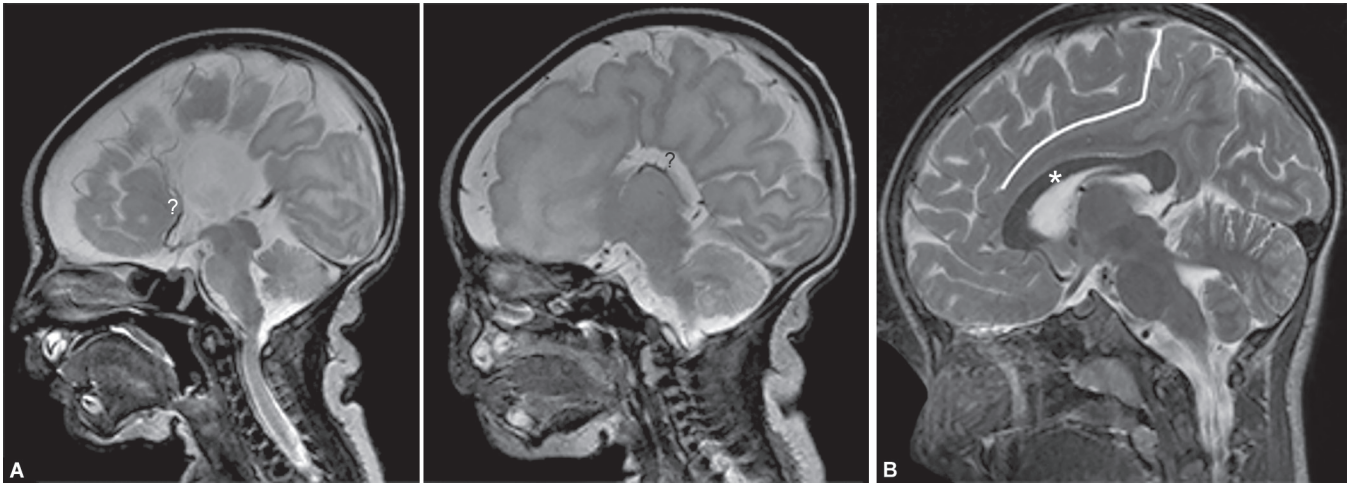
to D: Sagittal T2-weighted images of four infants with an abnormal shape and contour of the corpus callosum (CC) (marked by an asterisk, \*). Patients in images A and B show a maldeveloped, foreshortened, and thinned corpus. Patient C has a partially destroyed CC secondary to a large, chronic periventricular ischemic brain defect. Patient D shows a significantly thinned out, deformed CC (marked by a pi sign, Π). Due to a high-grade obstructive hydrocephalus caused by an aqueductal stenosis. This patient had rhombencephalosynapsis (midline fusion of both cerebellar hemispheres, complete absence of the midline vermis). Correct differentiation between malformation, destruction, and secondary thinning/ deformity due to a hydrocephalus is essential
